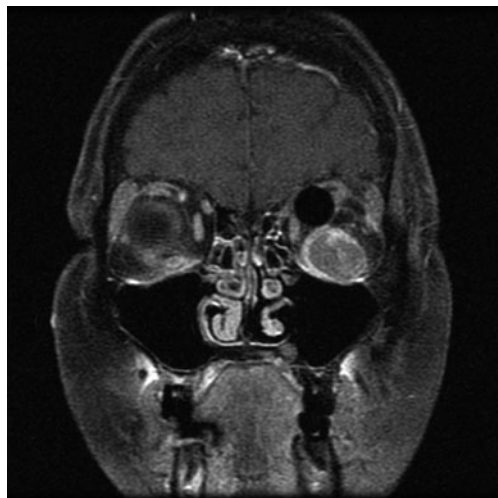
Magnetic resonance image of a left uveal melanoma with extension into the orbit. The patient has undergone enucleation. The uveal melanoma mass in the left orbit is pushing the orbital implant up
